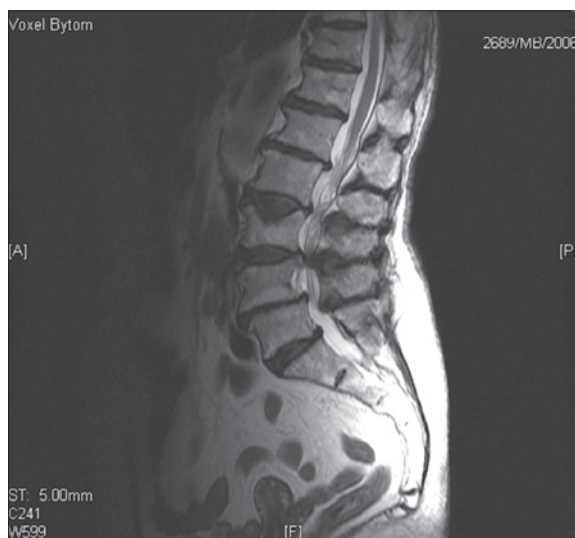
T2-weighted magnetic resonance scan obtained in a patient diagnosed with the RA subtype of myelodysplastic syndrome.
